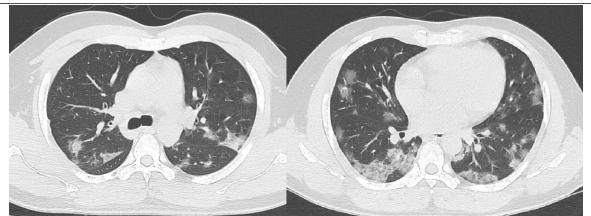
In a non vaccinated, non comorbid, 45 year old, COVID+ patient, axial CT thorax sections at the level of carina (left) and at the level of ventricles (right) reveals typical findings of COVID: Bilateral, multifocal, patchy ground glass opacities in predominant subpleural distribution involving all segments of bilateral lungs. CTSS was 10 (moderate lung involvement of 40-45%)
